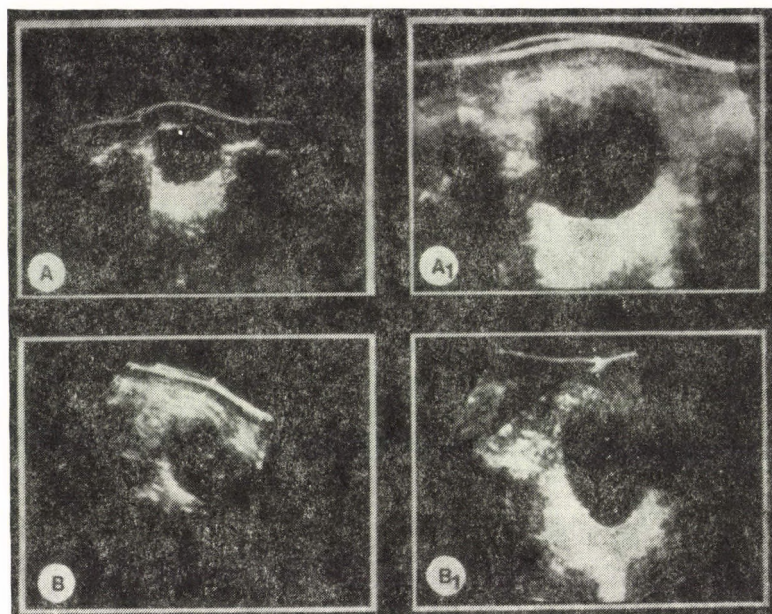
Measurement by ultrasound diagnosis of urinary retention without catheter.
